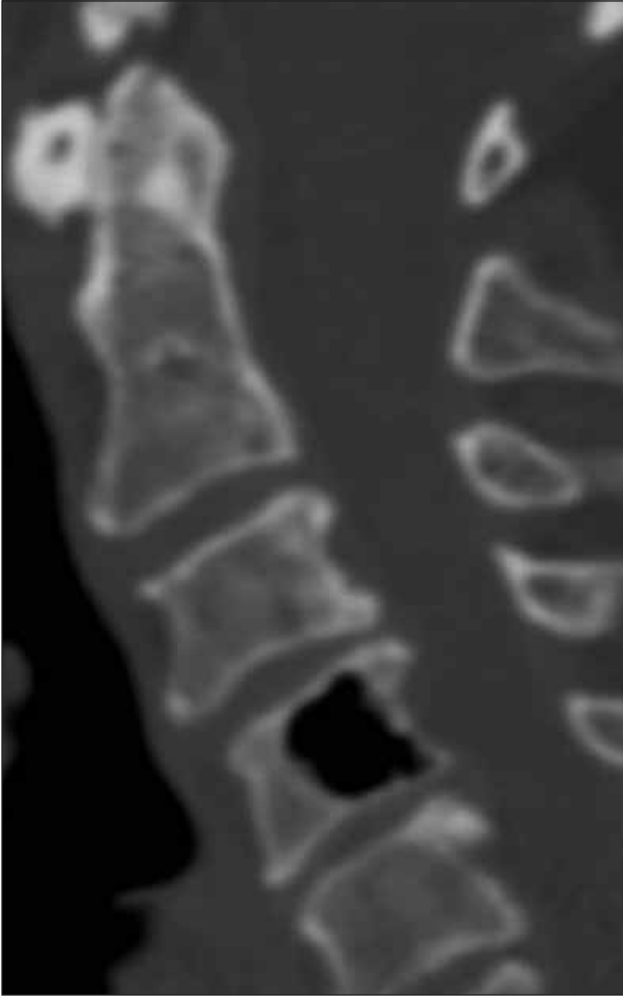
Sagittal section of cervical vertebrae CT showing pneumatocyst in the body of C4 vertebra.
